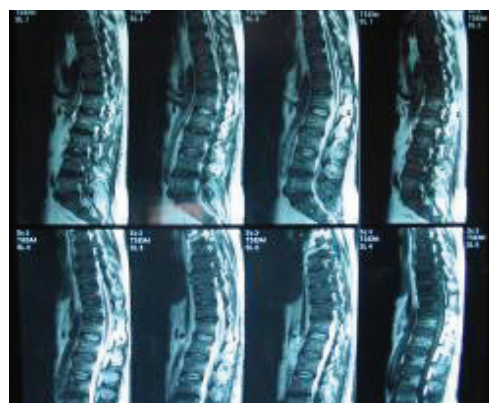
Thoracolumbosacral MRI of the patient
